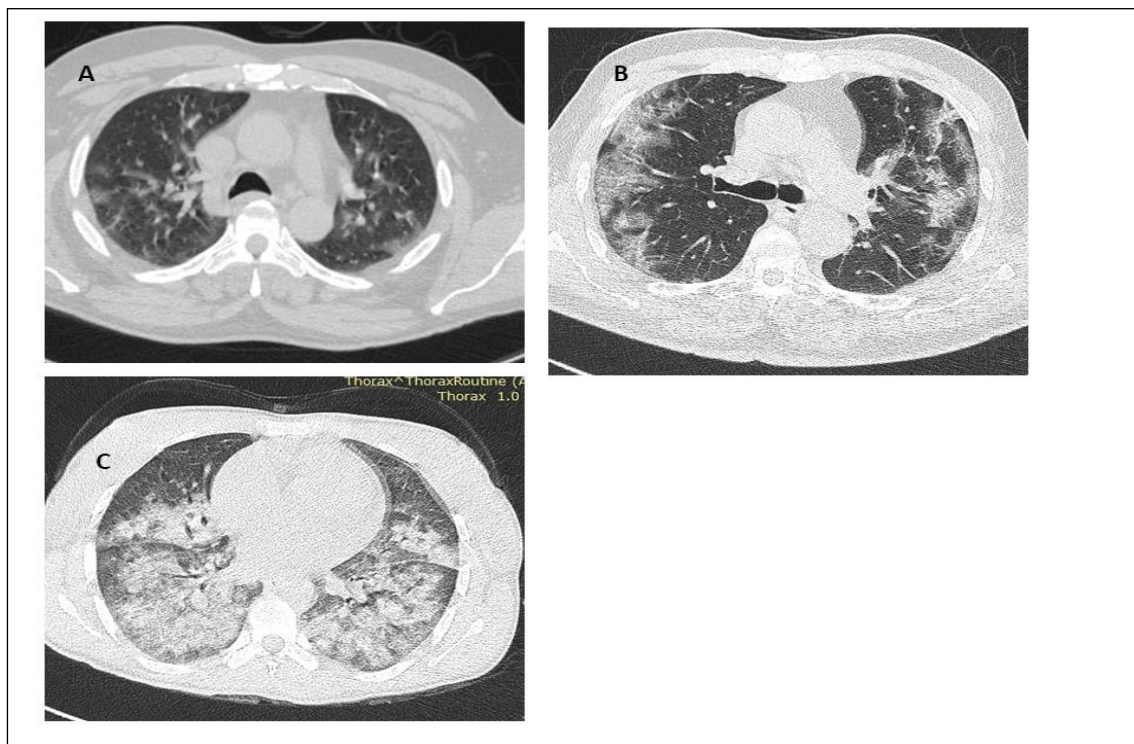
Non –enhanced chest CT scans of different patients with acute COVID-19 infection, showing different severity scores, from mild (A), moderate (B) to severe (C).
